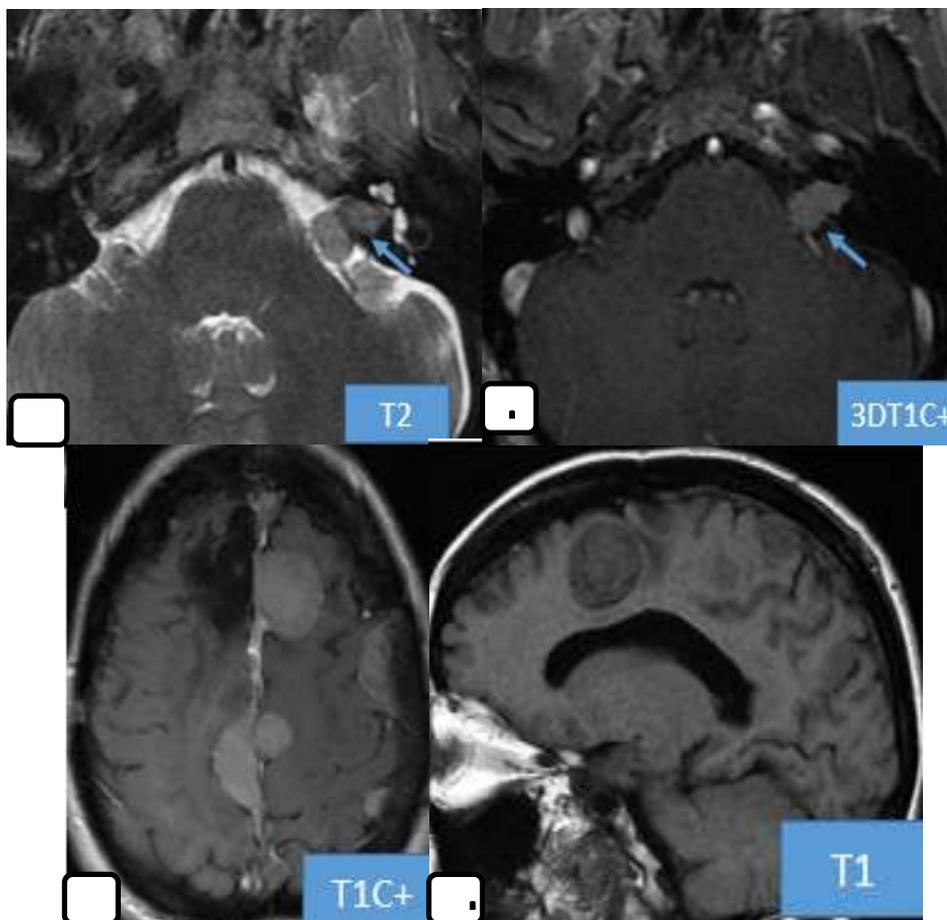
MRI in axial section in T2 sequence (a); in axial section in injected T1 sequence (b,c) and in sagittal section in T1 sequence: left vestibular schwannoma in discrete T2 hypersignal, enhanced after contrast (blue arrow) associated with multiple meningiomas in the setting of neurofibromatosis type 2
